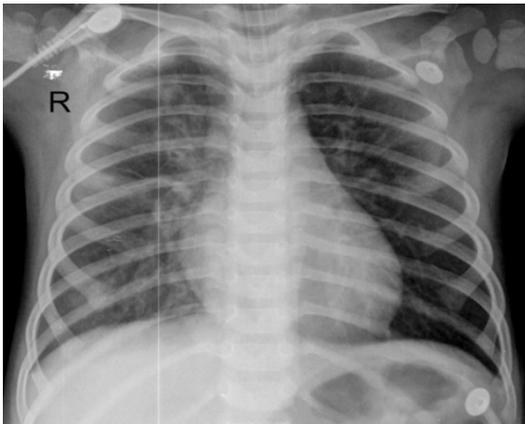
Chest radiography on August 23, 2016 showed a blurred image in the right upper lung and right lower lung. The brightness of the left lung was increased.
